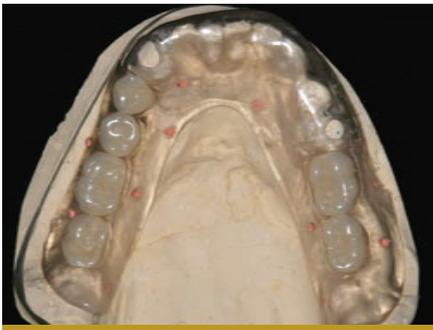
Radiographic guide fabrication using NobelGuide™ (Nobel Biocare AB, Göteborg, Sweden) treatment protocol.
